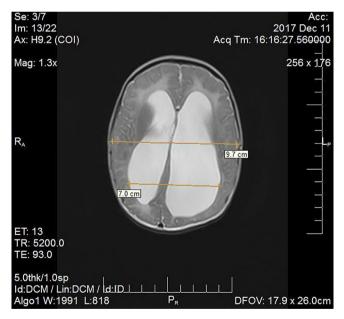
2 month baby, before surgery on MRI is presented severe degree of hydrocephalus with PHI 0.72.
